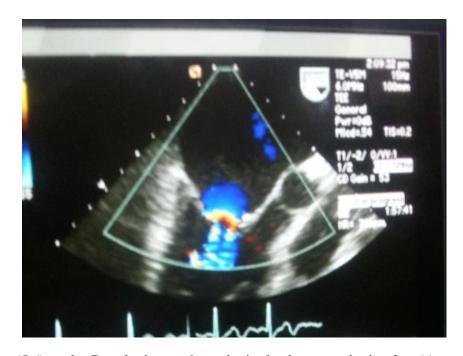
color Doppler image showed mitral valve regurgitation for 66 years old female.
